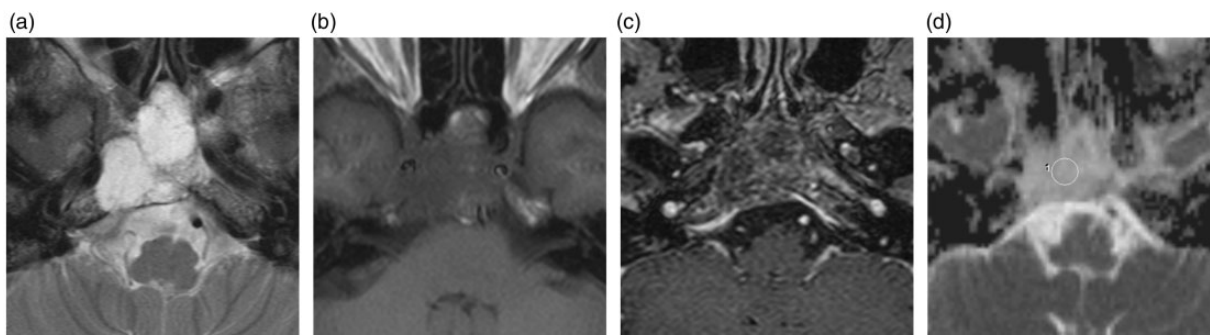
Conventional MRI tumor example and ADC example of an intratumoral ROI in a patient with classic clival chordoma. (a) T2W axial plane: hyperintense mass with low-signal intensity septations separating high-signal intensity lobules. (b) T1W axial plane: hypointense to brain parenchyma with two subtle hyperintense linear areas at the anterior tumor margin consistent with mucinous and/or small hemorrhagic areas. A fatty component is not likely as a differential diagnosis within the tumor matrix. (c) T1W postcontrast axial plane: heterogeneous small-to-moderate contrast enhancement. (d) ADC map: intratumoral ROI 18.7 mm², mean ADC 1297.3×10^{-6} mm²/s, SD 102.8×10^{-6} mm²/s.
